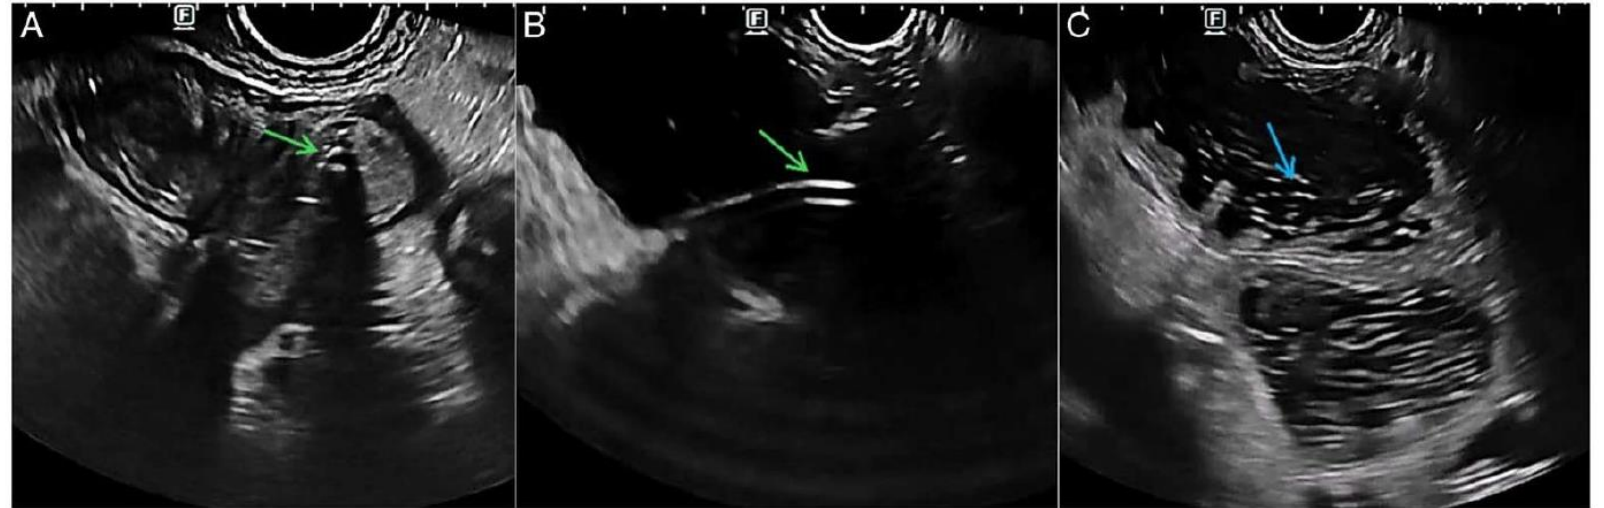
Endosonographic identification of the target jejunal loop. A–B, Visualization of the OJT tip inside the bowel loop lumen (green arrows) before (A) and after (B) fluid injection. C, Fluid turbulence within the bowel loop caused by saline injection through the OJT (blue arrow).
